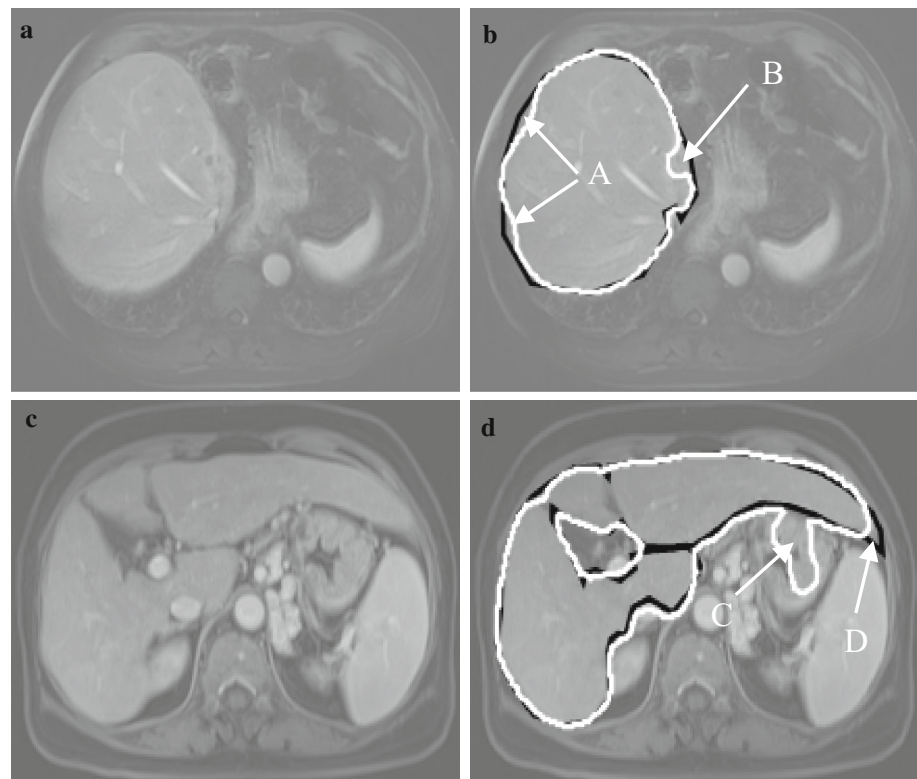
Comparisons between our fully automated computerized liver volumetry (*white contours*) and the gold standard manual volumetry (*black contours*) for a case (68-year-old man) with a high Dice coefficient (94.7%). a An axial MRI slice. b A computer contour (*white*) and a manual contour (*black*). c A different axial slice of the same patient. d A computer contour (*white*) and a manual contour (*black*)
